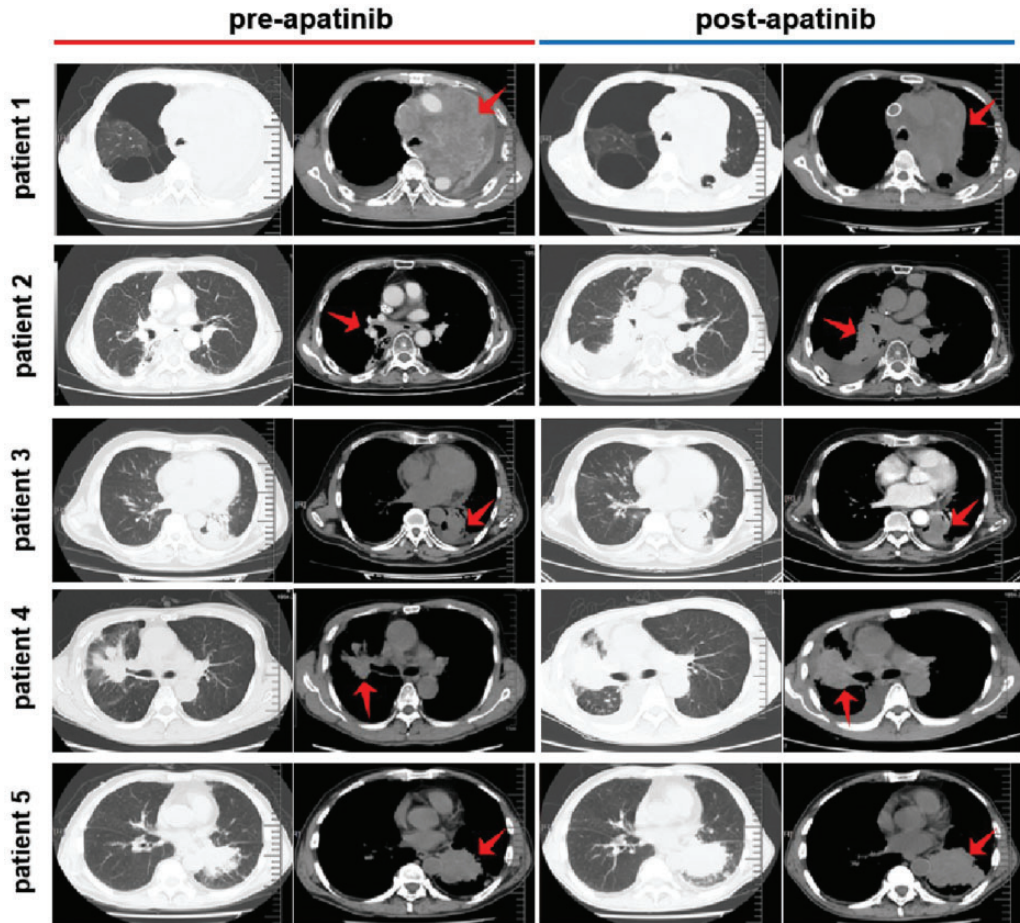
Computed tomography scans in five patients before and after apatinib monotherapy. Red arrows indicate tumor mass.
